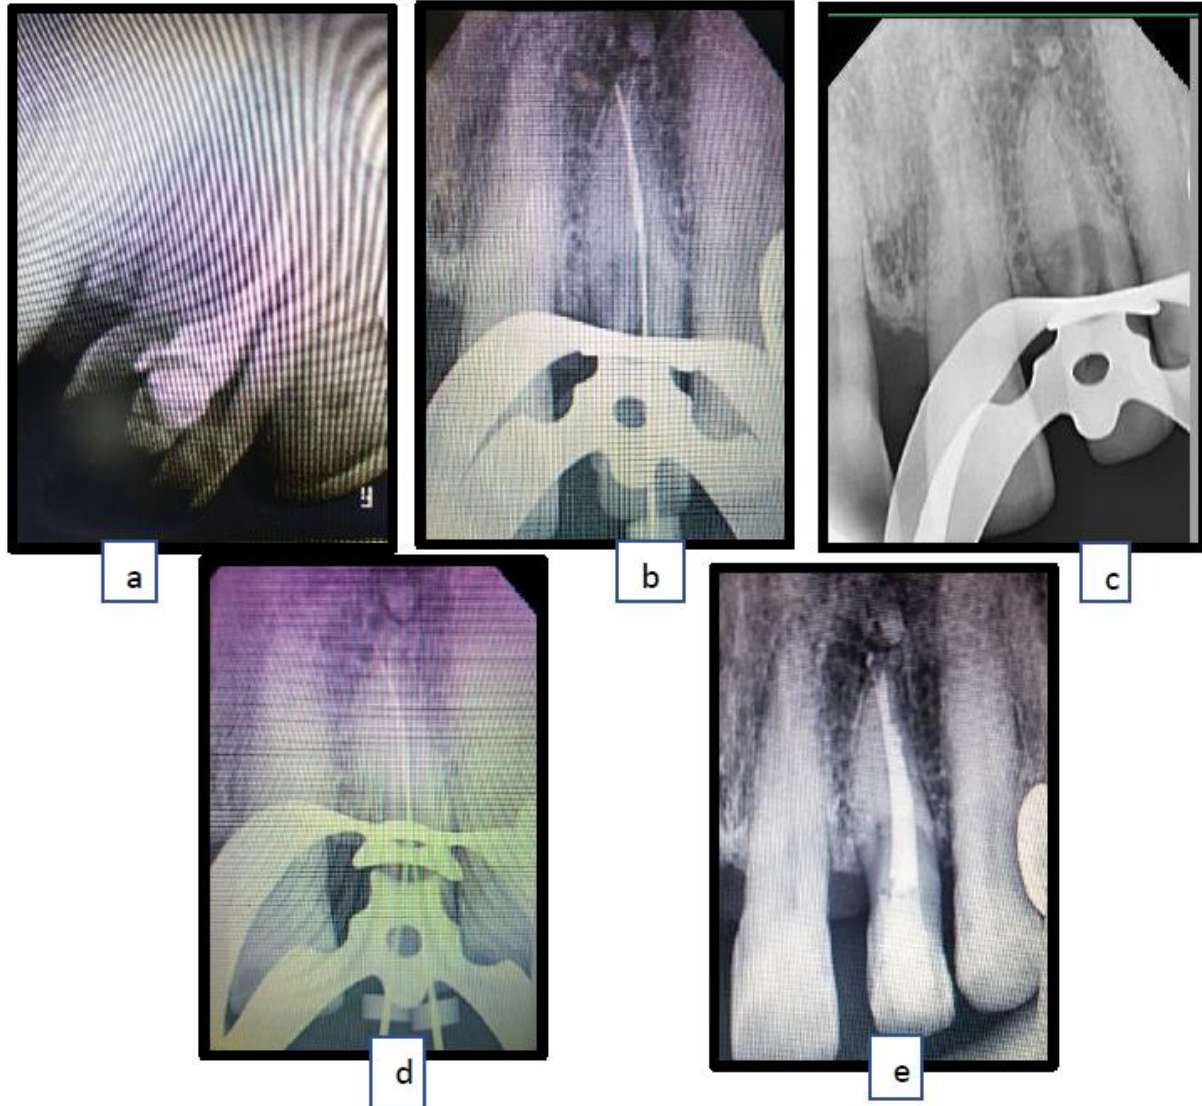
a. preoperative radiograph b. File bypassed c. File retrieved d. Working length e. obturation
